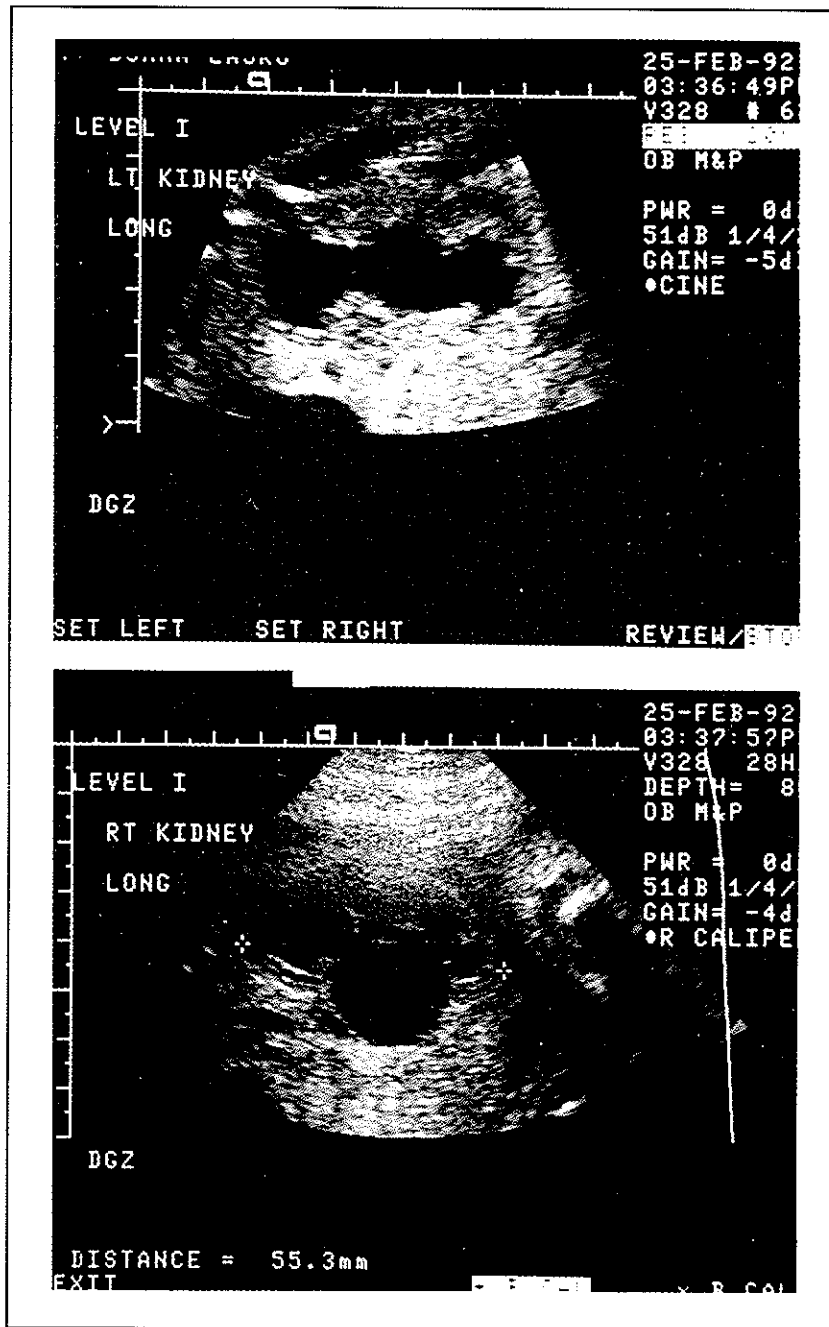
Prenatal ultrasonography. Bilateral hydronephrosis was detected during a routine obstetric ultrasound. May. 1992.
